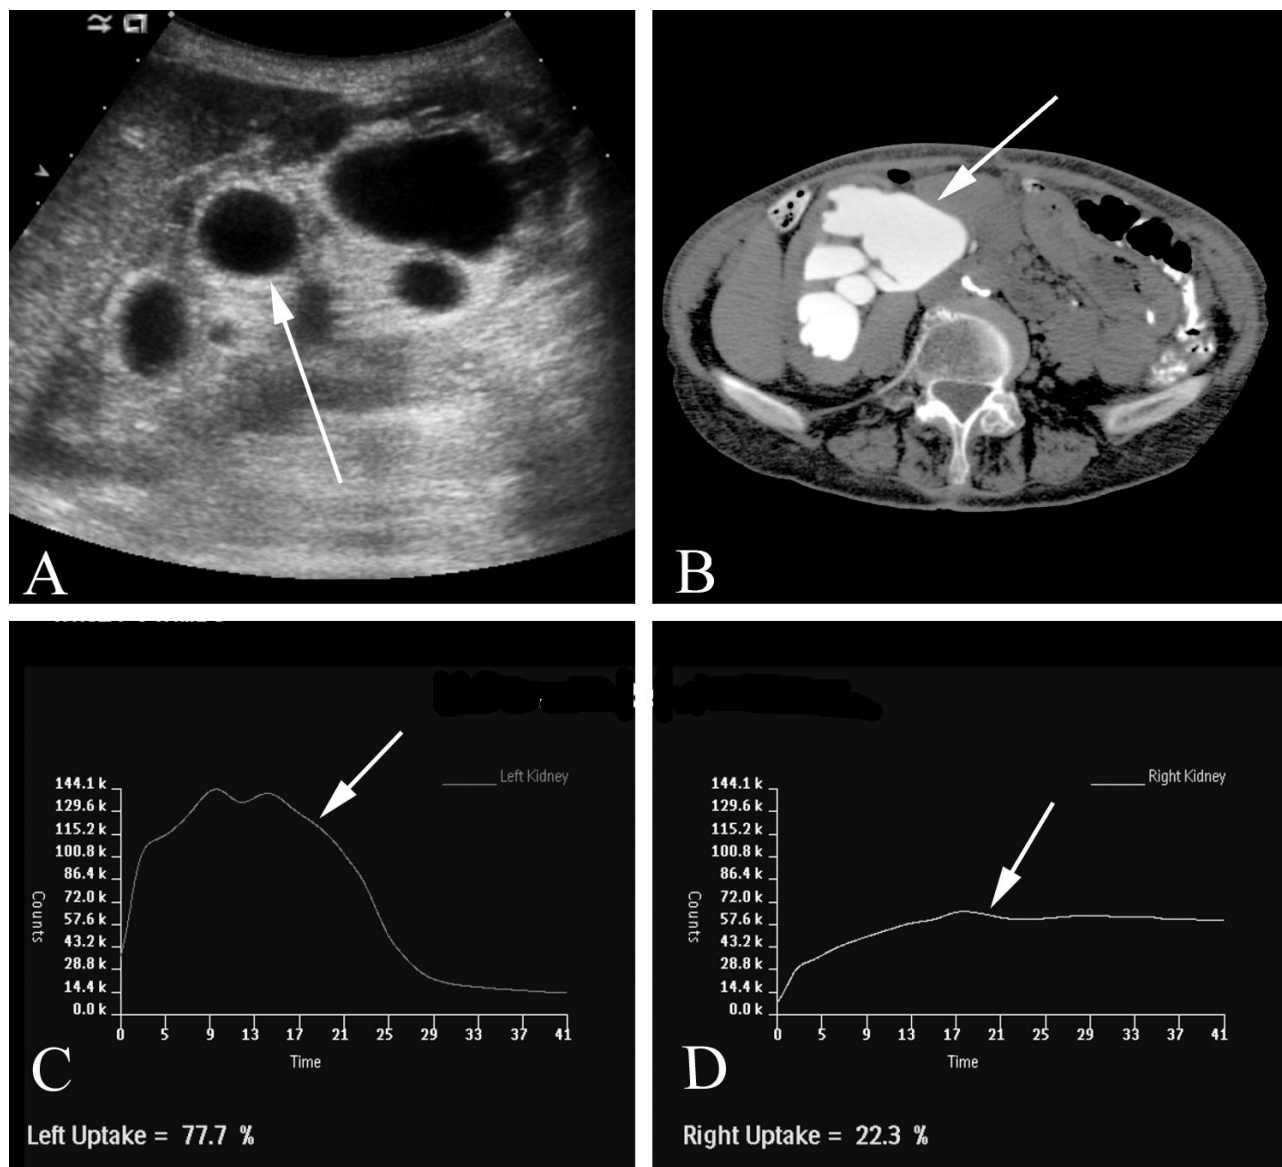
Ureteropelvic junction obstruction in a 57 year old woman with intermittent right upper quadrant pain. A. RUQ ultrasound examination showed a dilated right renal collecting system (arrow). B. Axial CT shows a dilated right collecting system (arrow). Both ureters (not shown) were of normal size. C. Nuclear medicine time activity curve for the left kidney (arrow) shows a normal appearance, with 77% of the measured excretion of injected radionuclide exiting the left side. D. Nuclear medicine time activity curve for the abnormal right kidney (arrow) shows a flattened appearance, with 23% of the measured excretion of injected radionuclide exiting the left side.
